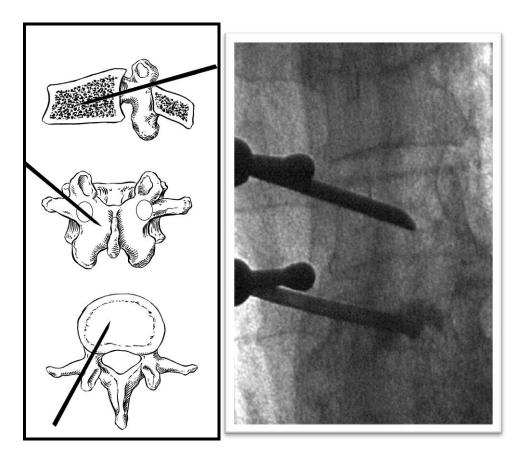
Under high resolution image guidance - either CT or biplanar fluoroscopy – the trocars are inserted safely via the pedicles into the vertebral body : "stay in the ring!". Images courtesy of Dr Richard Edwards.
